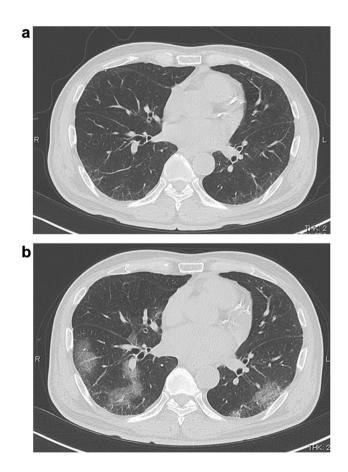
a Initial axial chest computed tomography images did not show any abnormalities suggesting COVID-19. b Axial chest computed tomography images in the second episode showed moderate ground-glass opacities in bilateral lungs
